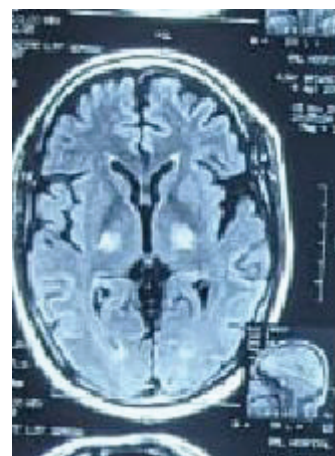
FLAIR weighted image MRI brain showing hyperintensity involving bilateral thalamus
